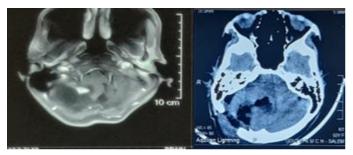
Preoperative MRI axial image and postoperative CT axial image-pilocytic astrocytoma.
